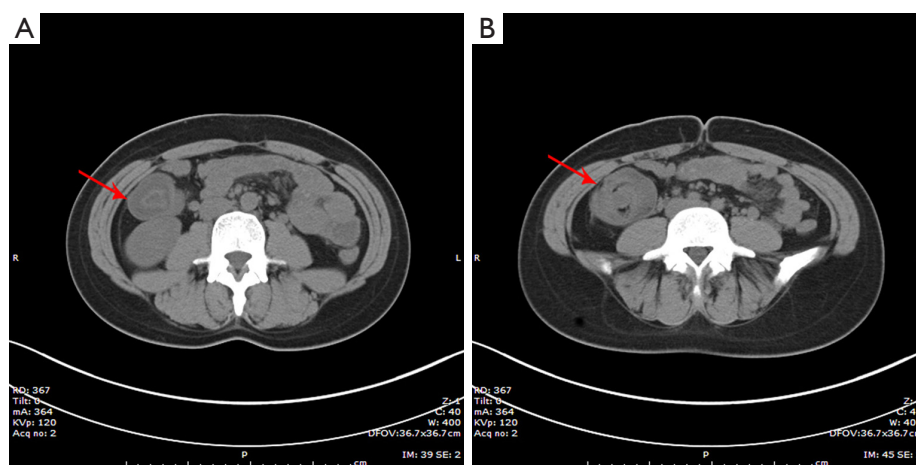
CT images. As the arrows (→) indicate, abdominal CT showed: (A) a “target-like” sign, the appendix surrounded by a rim of digestive structures, typical of appendiceal intussusceptions and (B) a well-encapsulated cystic mass surrounded by the caecum, just as the “cup-and ball” pattern, which is the appearance of the appendiceal mucocele surrounded by the caecum.
